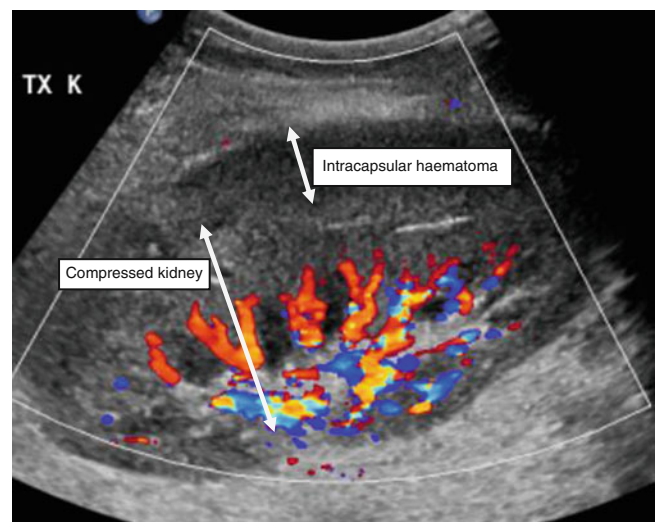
Prone ultrasound, same patient
